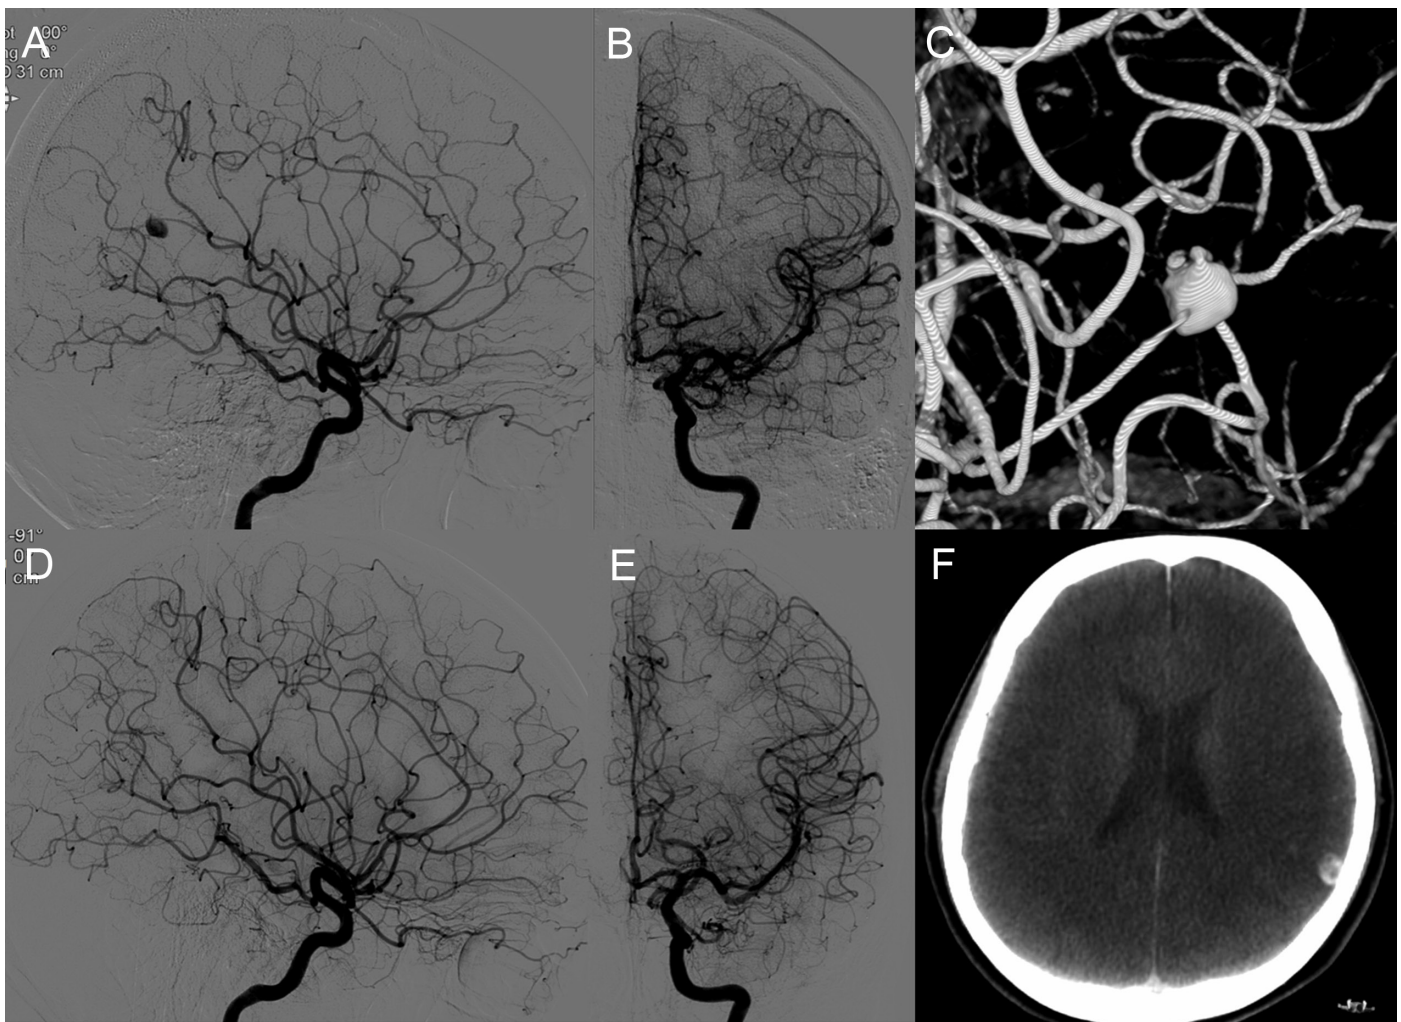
(A, B) The mycotic aneurysm, that was detected on left MCA posterior parietal artery distal branch in an 18-year-old patient, was shown in lateral and Anteroposterior (AP) digital subtraction angiographic views obtained via left internal carotid artery (ICA) injection. (C) 3D reconstruction image of the mycotic aneurysm. (D) Lateral and (E) AP digital subtraction angiographic views obtained at the beginning of the treatment session revealed spontaneous occlusion of the aneurysm. (F) Control cranial computed tomography following the spontaneous occlusion of the aneurysm showed the hyperdense nodular lesion (thrombosed aneurysm) on the left parietal region.
